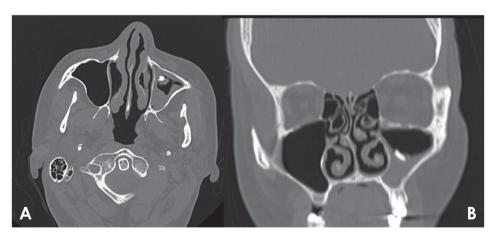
A. An axial cone-beam computed tomographic (CBCT) image shows an iron-like opacity surrounded by dense tissue and mucosal thickening in the sinus walls. B. CBCT image on the coronal plane shows the lesion in the left maxillary sinus.
